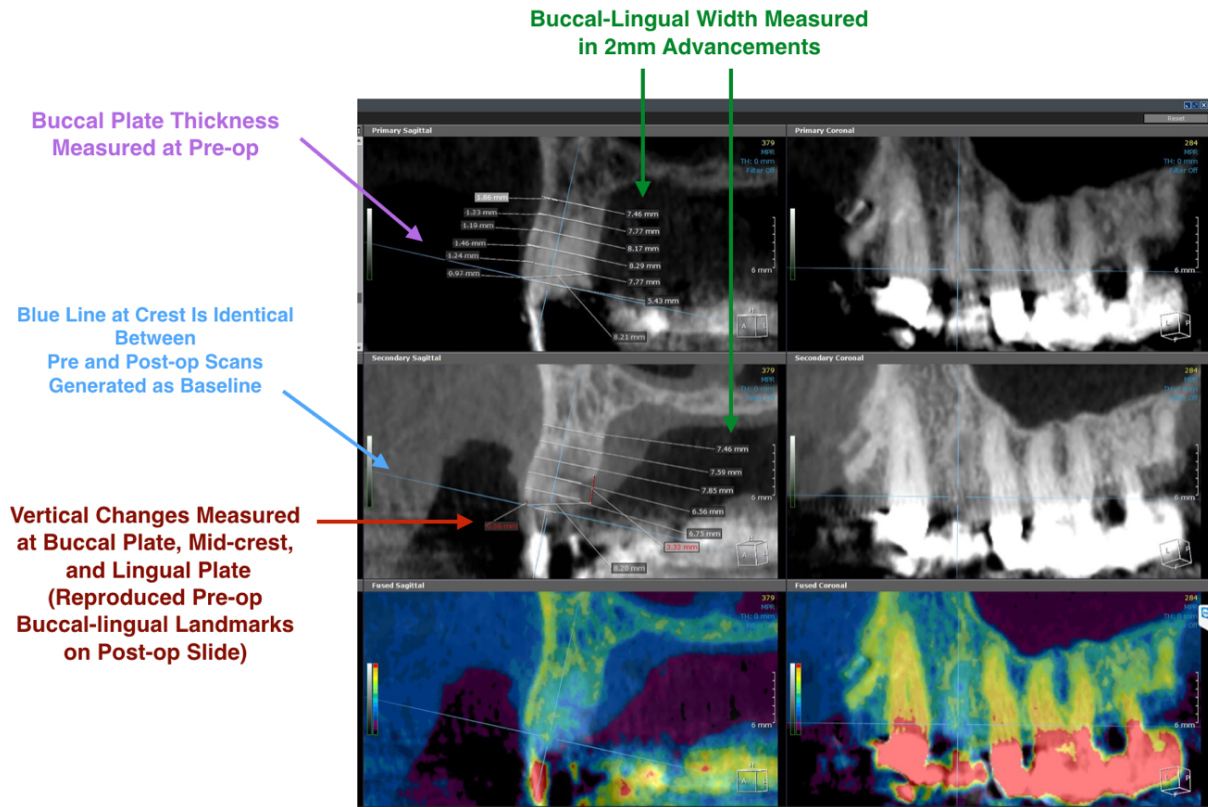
Superimposition of pre-operative and post-operative CBCT Scans
